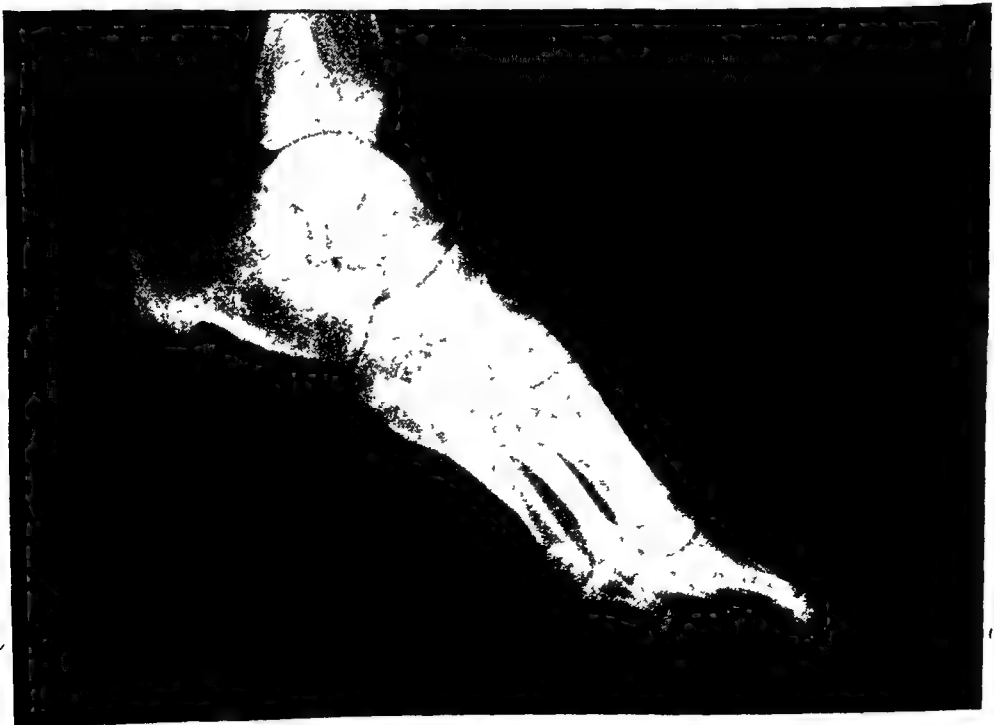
RADIOGRAPH OF RECUMBENT FOOT.
